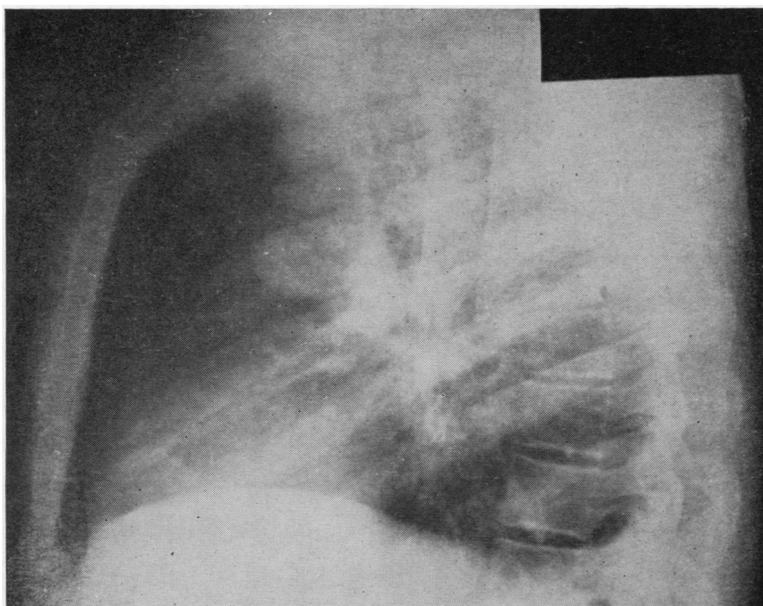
Left lateral radiograph showing the round opacity related to a branch of the pulmonary artery, and a related anterior segmental lesion.
